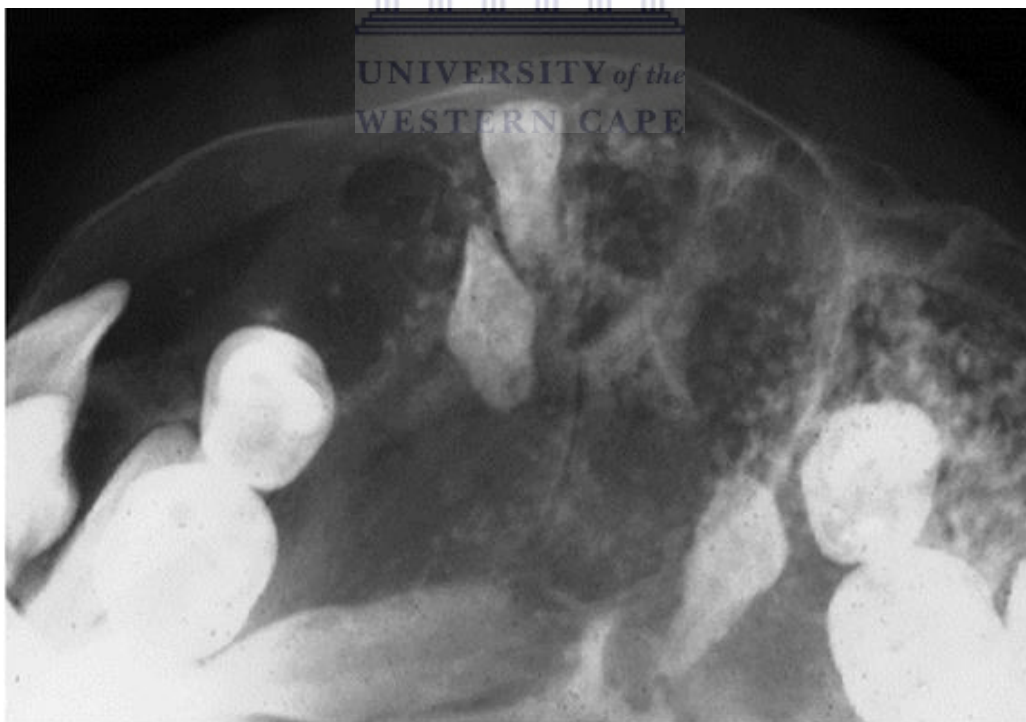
A standard maxillary occlusal radiograph showing fine radiopaque changes within the intrafollicular lesion. Note the presence of impacted teeth and the displacement of the adjacent teeth. Photo: Courtesy Prof CJ Nortje
